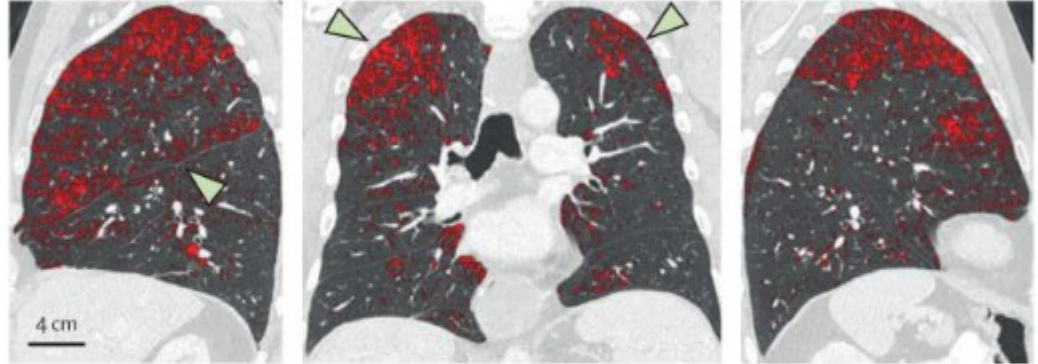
Conventional chest x-rays, dark-field chest X-rays, CT, and pulmonary function testing for an example patient (male, aged 58 years, body-mass index  $27.6 \text{ kg/m}^2$ , 35 pack-years)
